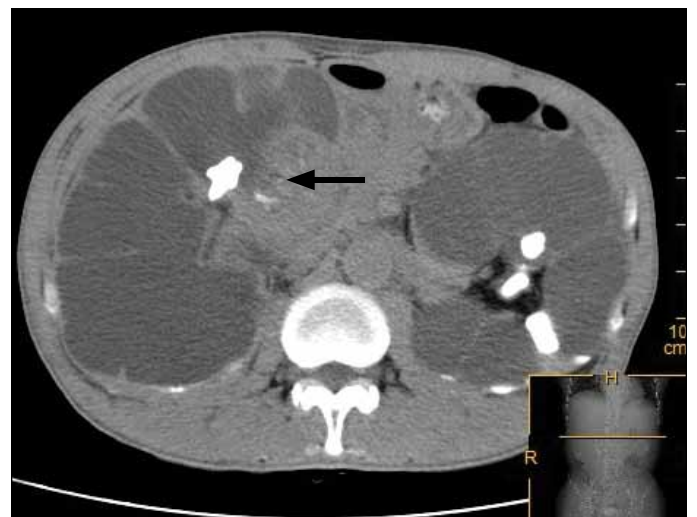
Non-enhanced computed tomography showing a mass in the right renal pelvis with calculus (shown by an arrow).
